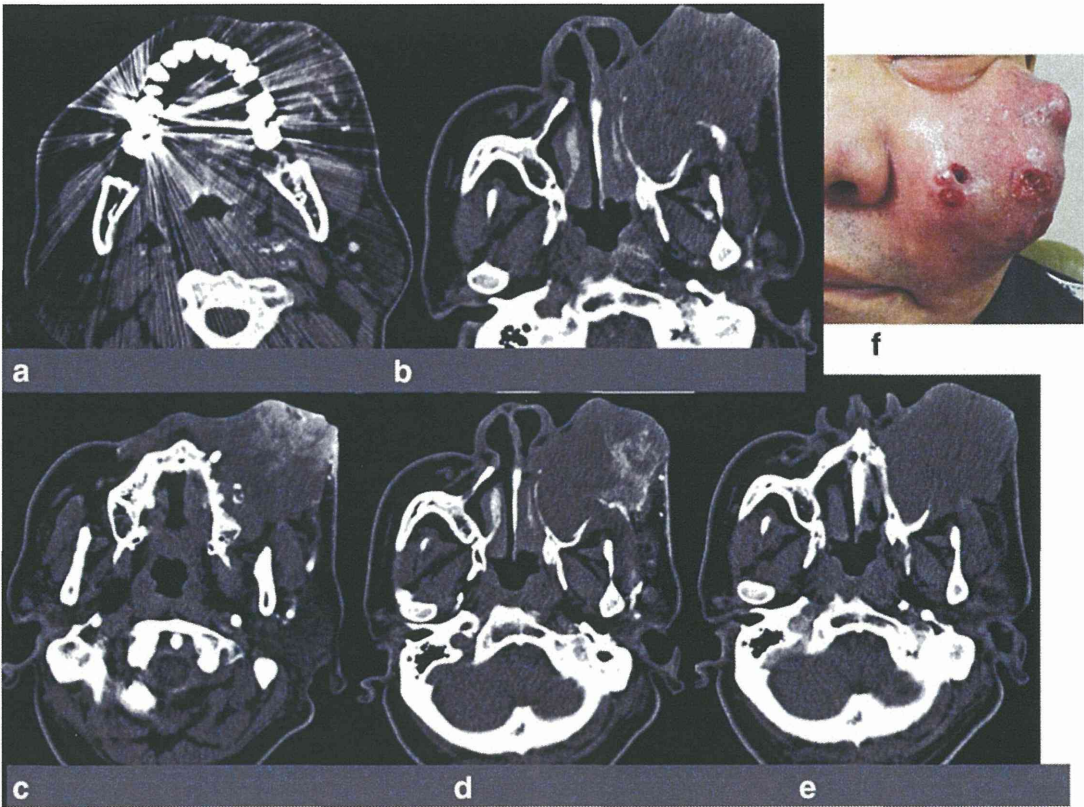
Case 1: a 66-year-old man with maxillary cancer (T4AN2bM0). a CT angiography obtained in the selected left side maxillary artery. It was difficult to confirm the vascular territory due to dental metals. b CT angiography obtained in the selected left side maxillary artery. It was difficult to confirm the vascular territory due to obstacle enhancement. c CT angiography obtained in the selected left side facial artery. It was sufficiently clear to confirm the vascular
